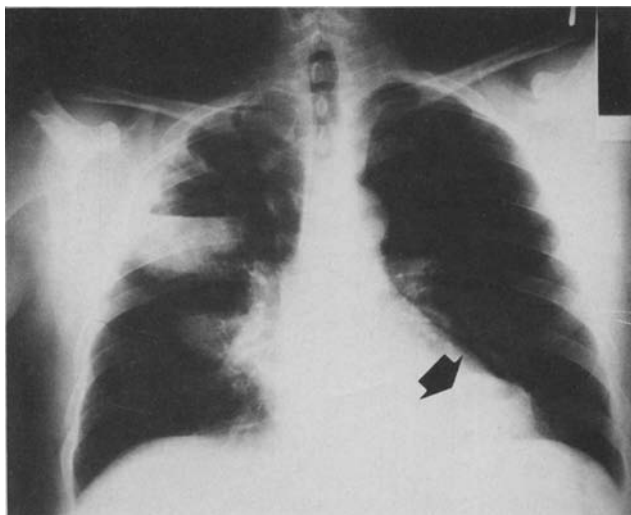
Chest roentgenogram demonstrating two cavitary lesions and air-fluid levels, one in the right upper lobe and another in the left lower lobe (black arrow). Note the parenchymal infiltrate in the right middle lobe.
